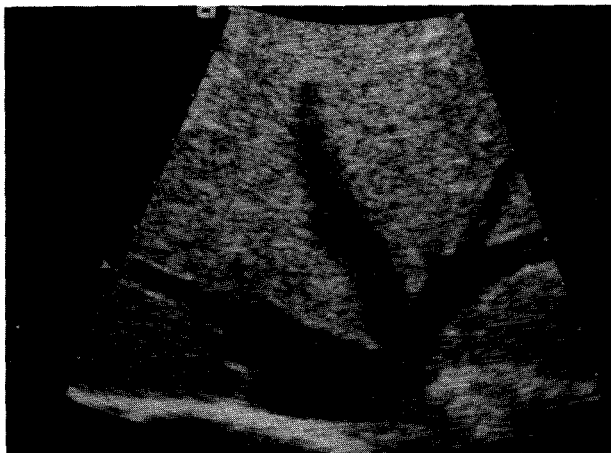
Ultrasound of the donor liver showing retrohepatic vena cava, left (LHV), median (MHV) and right (RHV) veins.
